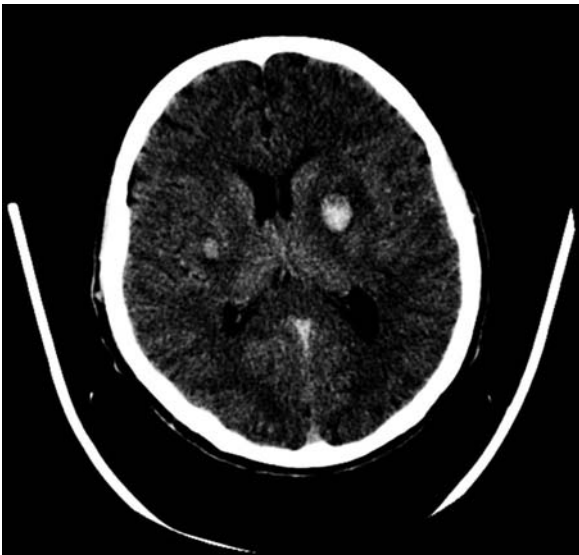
Cerebral computed tomography. Brain metastases.
